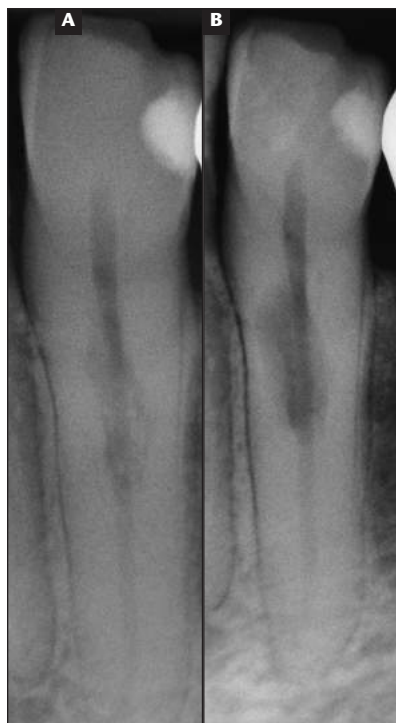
Extracanal invasive resorption can be identified in the radiograph of this mandibular cuspid. A previous radiograph demonstrated little or no change in the radiographic appearance over a period of 5 years.
